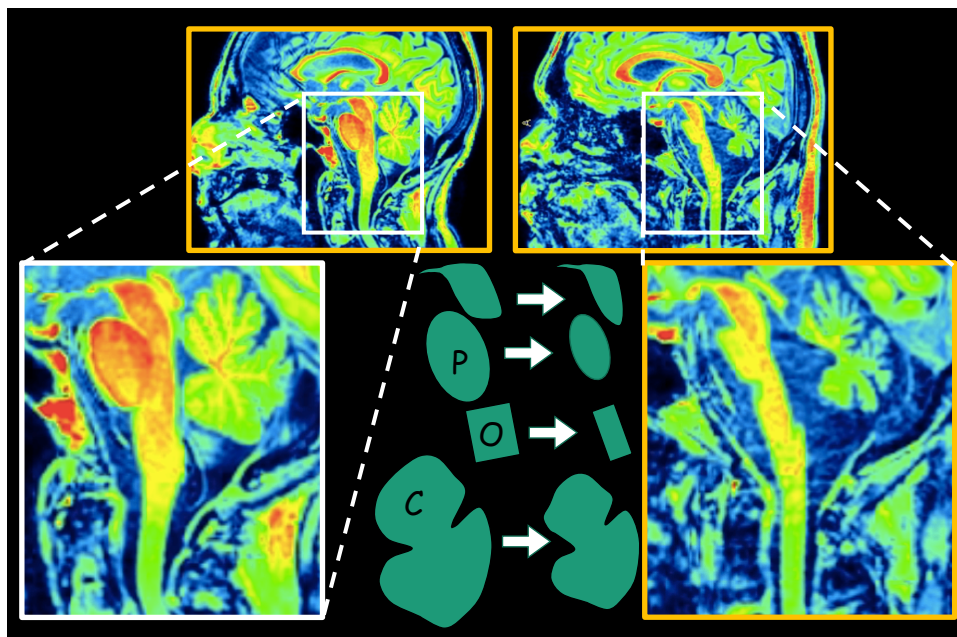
MRI in MSA-C. This patient clinically had the cerebellar form of multiple system atrophy (MSA). Magnetic resonance imaging (MRI) showed atrophy of the ventral medulla (the olivary nucleus region, O), pons (P), and cerebellum (C). That is, the patient had olivopontocerebellar atrophy (OPCA). He also had midbrain atrophy ().*
